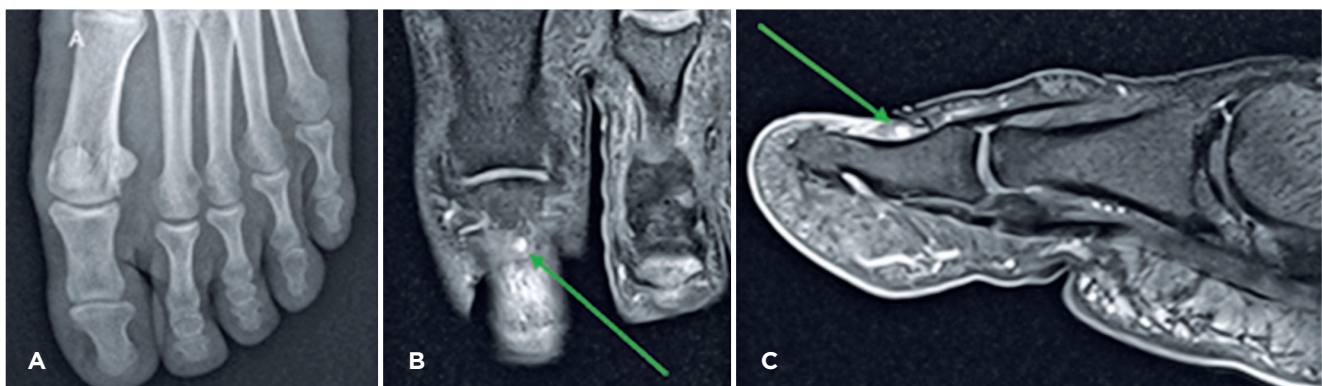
A) Anteroposterior radiograph of the left foot under load. B) Coronal T2-weighted magnetic resonance imaging with contrast showing a hyperintense lesion. C) Sagittal T2-weighted magnetic resonance imaging with contrast demonstrating enhancement in the central portion of the hallux nail matrix, measuring approximately 2.5 mm.
